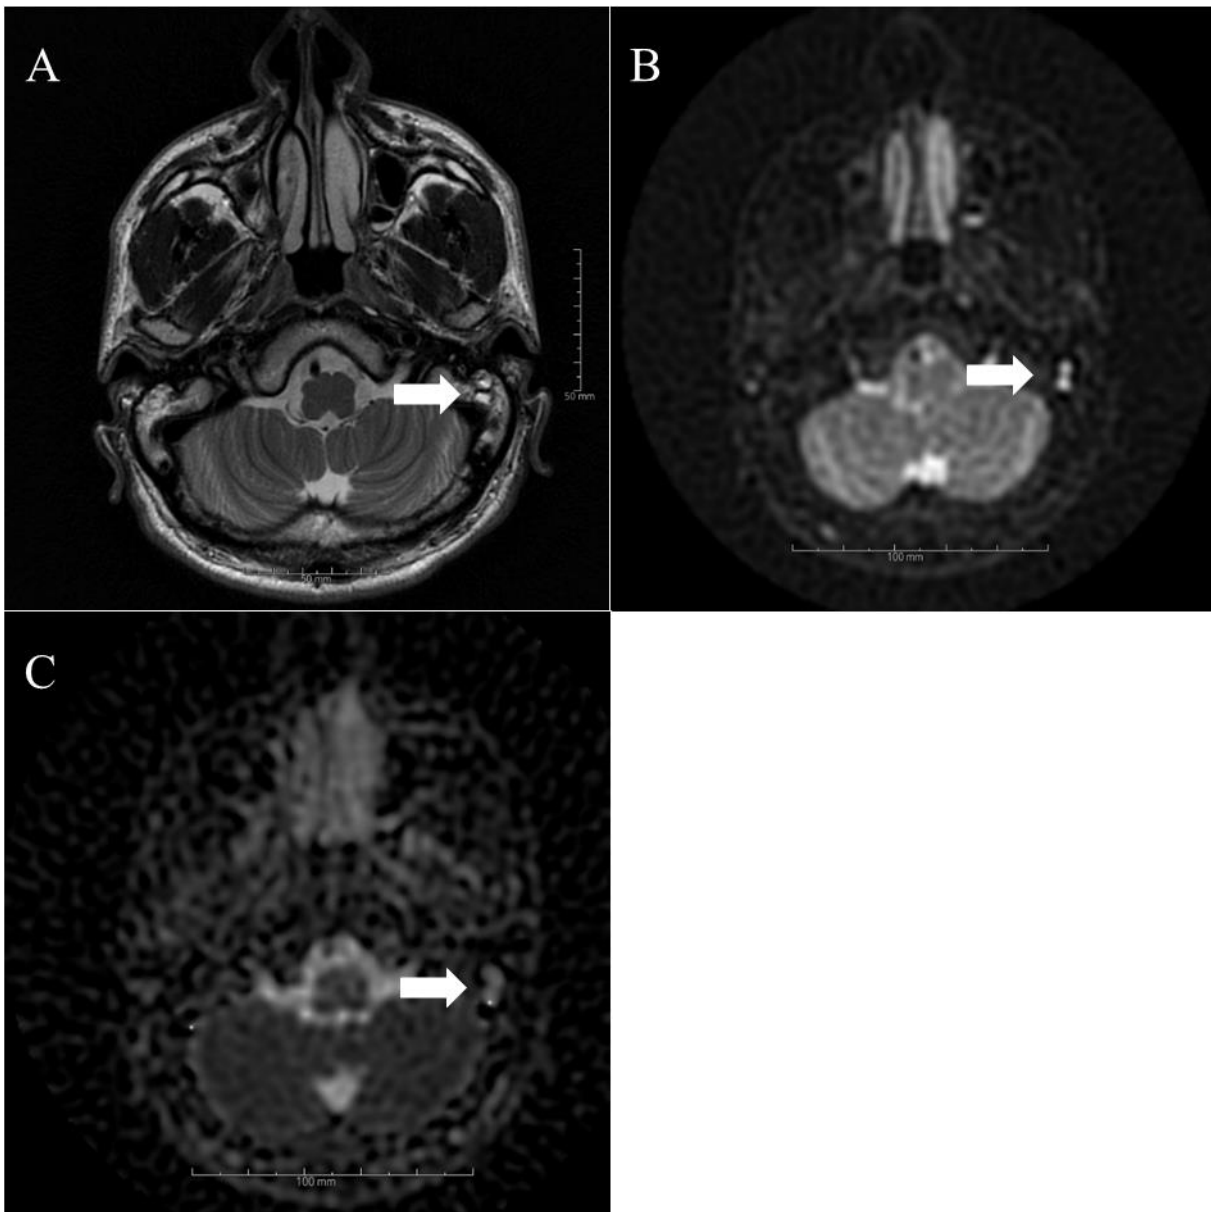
MRI visualization of granuloma/inflammation in the left middle ear. A30-year-old male. The otologic examination was obscured by cartilage reconstruction and an opaque tympanic membrane. The white arrows in all images point to the granuloma. a) MR imaging shows a slightly hyperintense signal on T2WI and b) ROPELLER DWI shows hyperintensity in this same area. d) The ADC map presents with hyperintense signal. Surgical findings confirmed the presence of inflammation in this region.
